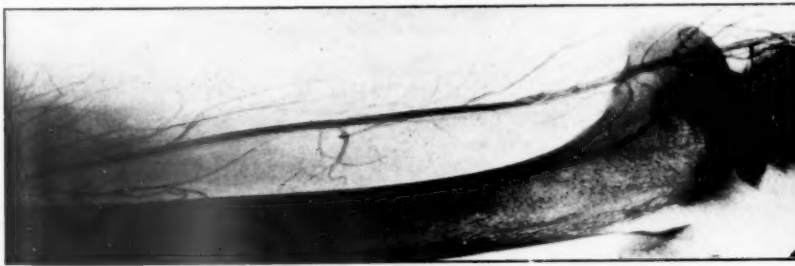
Shows extensive recanalization of thrombus in the popliteal artery. This appearance was constant on two successive radiographs.
